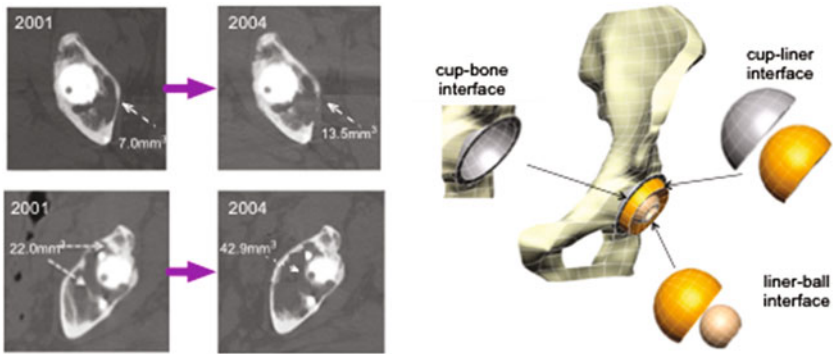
The volume of defects measured from CT scan. The volume of defects increased over 3 years period both in cancellous and cortical bones (*left*) and the interfaces incorporated in the FE model (*right*)
